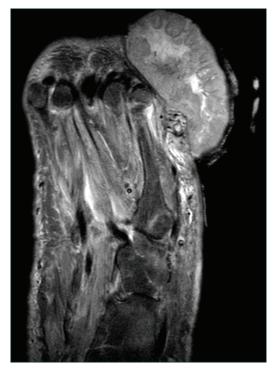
(left) STIR MRI of soft tissue mass.
